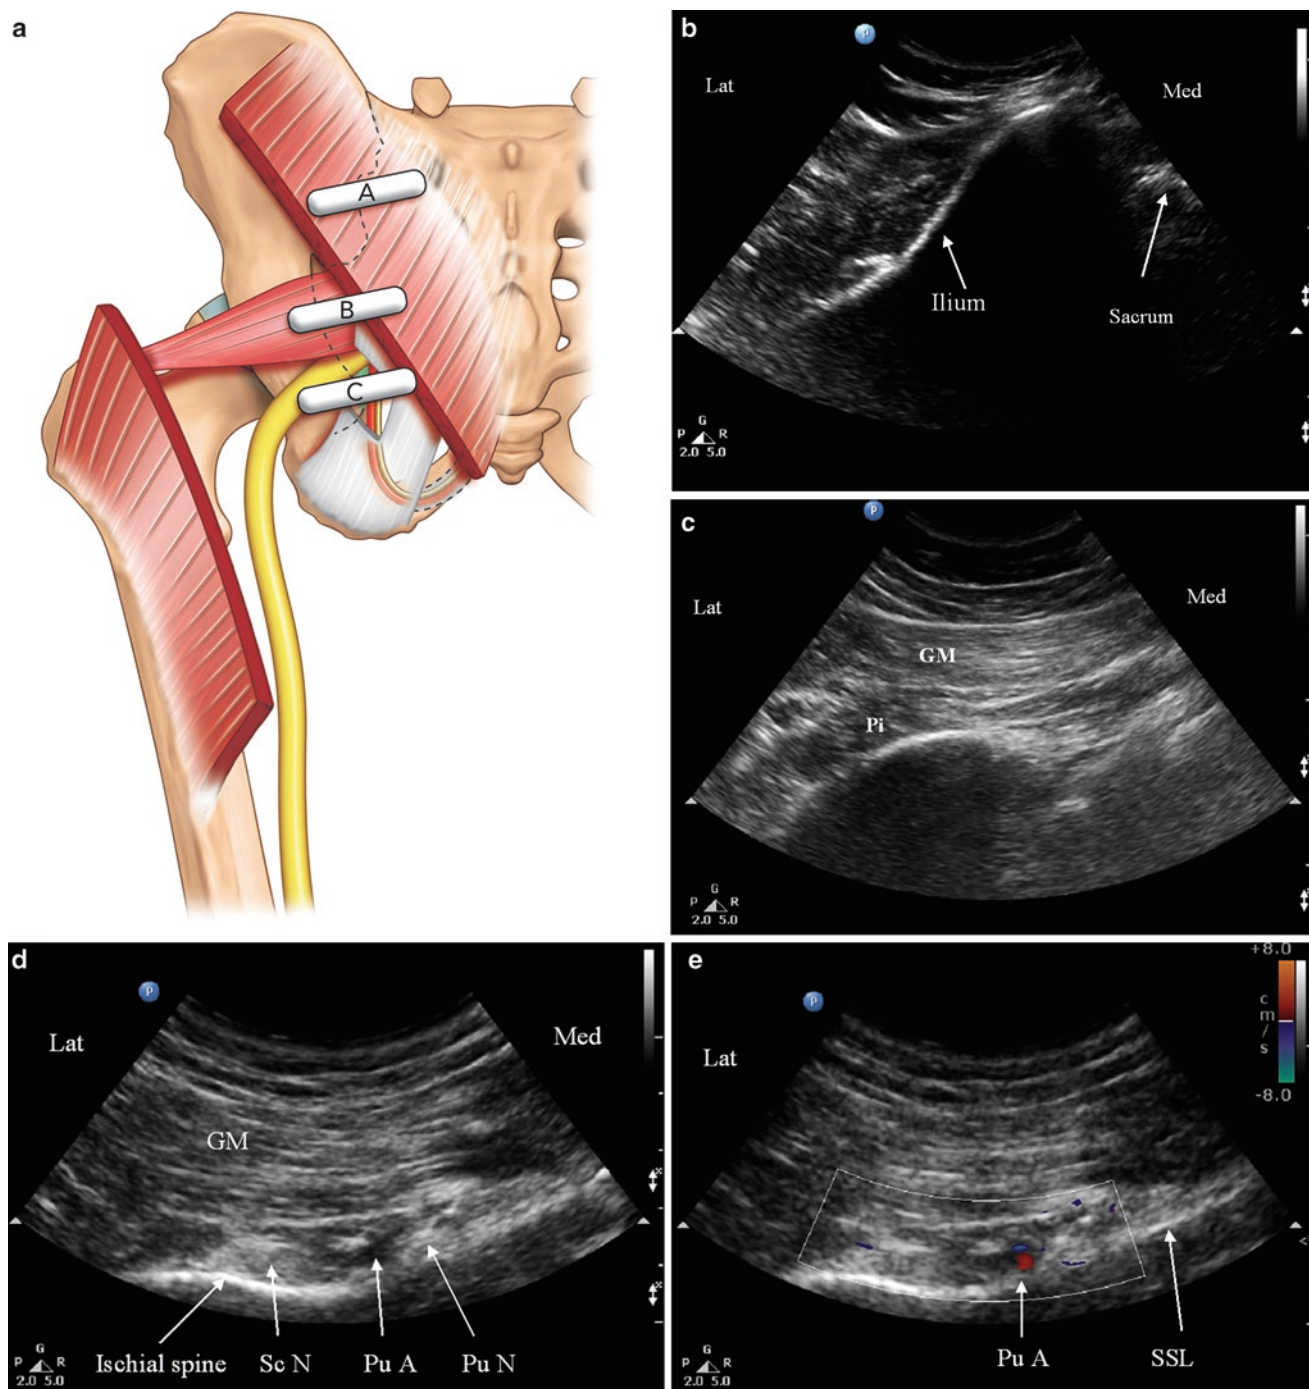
Ultrasonographic scan of the piriformis muscle and the pudendal nerve. (a) Three different positions of ultrasound probe. Reproduced with permission from USRA (www.usra.ca). (b) Ultrasound image at probe position A. (c) Ultrasound image at probe position B. (d) Ultrasound image at probe position C. (e) Color Doppler to show pudendal artery. *Pu A* pudendal artery, *Pu N* pudendal nerve, *SSL* sacrospinous ligament, *Sc N* sciatic nerve, *GM* gluteus maximus muscle. (b–e) From Rofaef et al.⁷ Reproduced with permission from Lippincott Williams & Wilkins.
